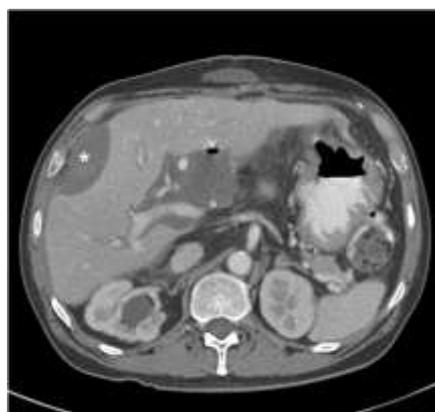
Axial iv contrast-enhanced CT image in a febrile patient demonstrates a complex porta hepatis fluid collection (*arrowhead*) that contains a single focus of gas consistent with an abscess. An additional pericapsular/subdiaphragmatic fluid collection is seen (*asterisk*).
